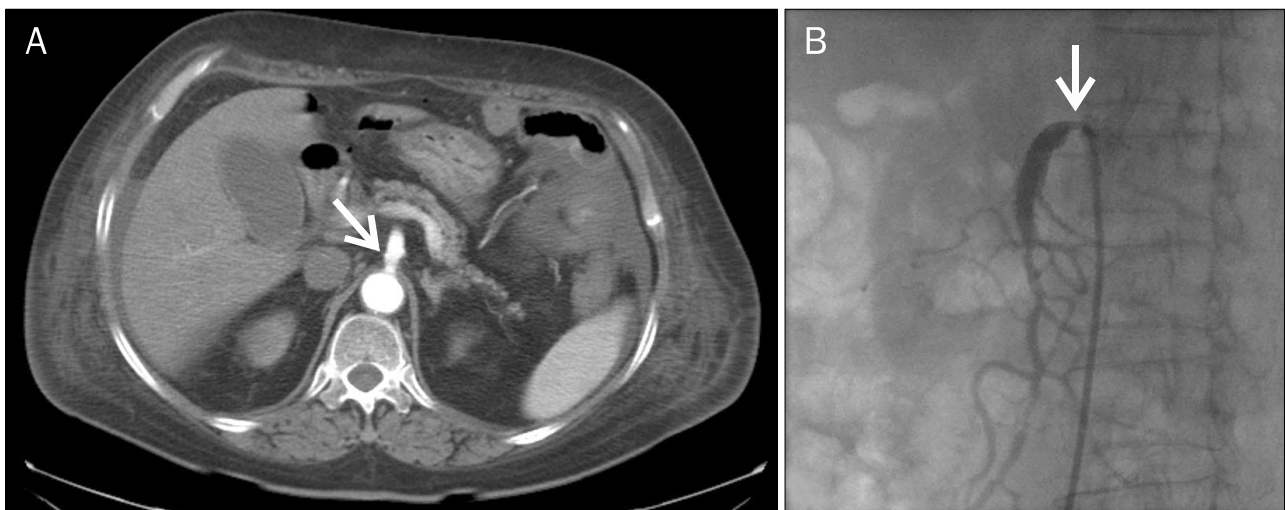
Abdominal CT and percutaneous angiography in case 2. (A) A filling defect was revealed in the ostium of the SMA and proximal portion in the abdominal computed tomography. Arrow indicates a thrombotic stenosis. (B) Severe stenosis (arrow) is shown in the proximal portion of the SMA in the percutaneous angiography.
